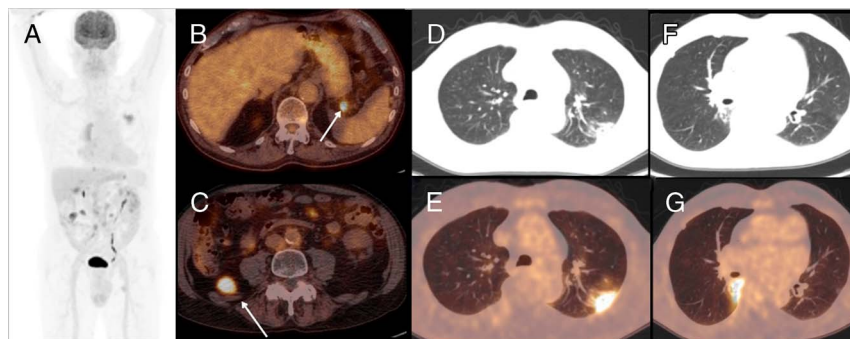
An asymptomatic 77-year-old man with non-Hodgkin lymphoma treated previously with one line of chemotherapy underwent an ¹⁸F-FDG PET/CT showing increased FDG uptake to several abdominal nodes consistent of relapse (A–C) and the presence of bilateral pleural thickening and FDG-avid GGOs with SUV_{max} of 10.2 (D–G). After the appearance of dyspnea and breathing difficulty, he went to the emergency unit and was hospitalized and started treatment with hydroxychloroquine.
